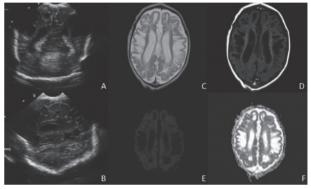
Head ultrasound, coronal (A) and parasagittal left (B) view, at 10 days of age shows subcortical cystic lesions and a wider interhemispheric fissure. Brain magnetic resonance, T2-weighted image (C), T1-weighted image (D), diffusion and apparent diffusion coefficient map (E/F), at 14 days of age shows extensive multicystic leukoencephalopathy in both hemispheres, predominantly subcortical.
